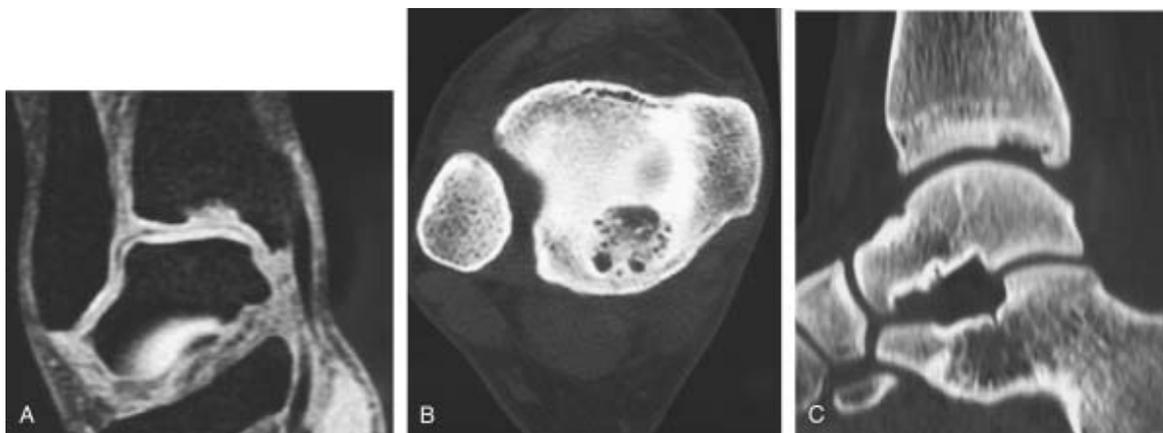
10 Osteochondral lesion of the distal tibia in a female collegiate basketball player. A, Coronal fat-suppressed magnetic resonance imaging. B, Axial computed tomography (CT) shows posterior-central lesion and small subchondral cysts. C, Sagittal CT shows depth of the defect. (From Mologne TS, Ferkel RD: *Arthroscopic treatment of osteochondral lesions of the distal tibia*. *Foot Ankle Int* 28:865-872, 2007.)
